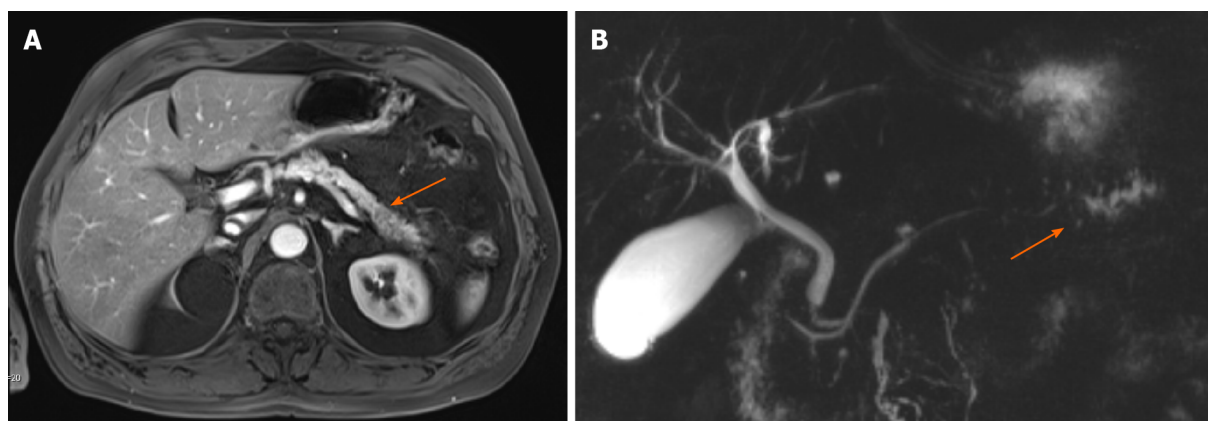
Abdominal computed tomography imaging of acute pancreatitis. In the pancreatic tail, a dilatation of the pancreatic duct can be observed.
